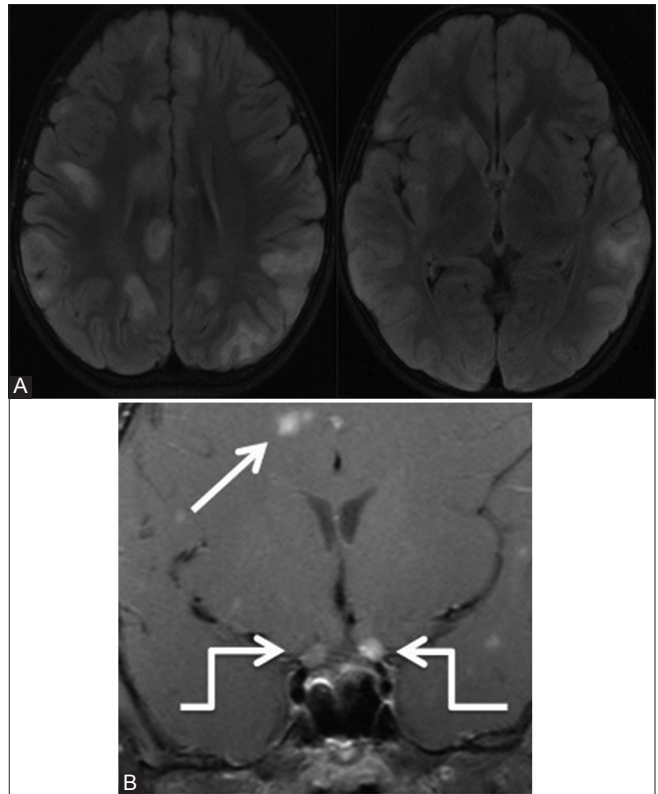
(A and B): Demyelination: ADEM. Axial FLAIR (A) and coronal post-contrast T1W (B) images of an 8-year-old female with sudden vision loss and altered behavior show multiple hyperintense lesions mainly in bilateral subcortical white matter and in right basal ganglia. There is enhancement of both the prechiasmatic optic nerves (elbow arrow). Few other enhancing lesions are seen in brain (arrow)
